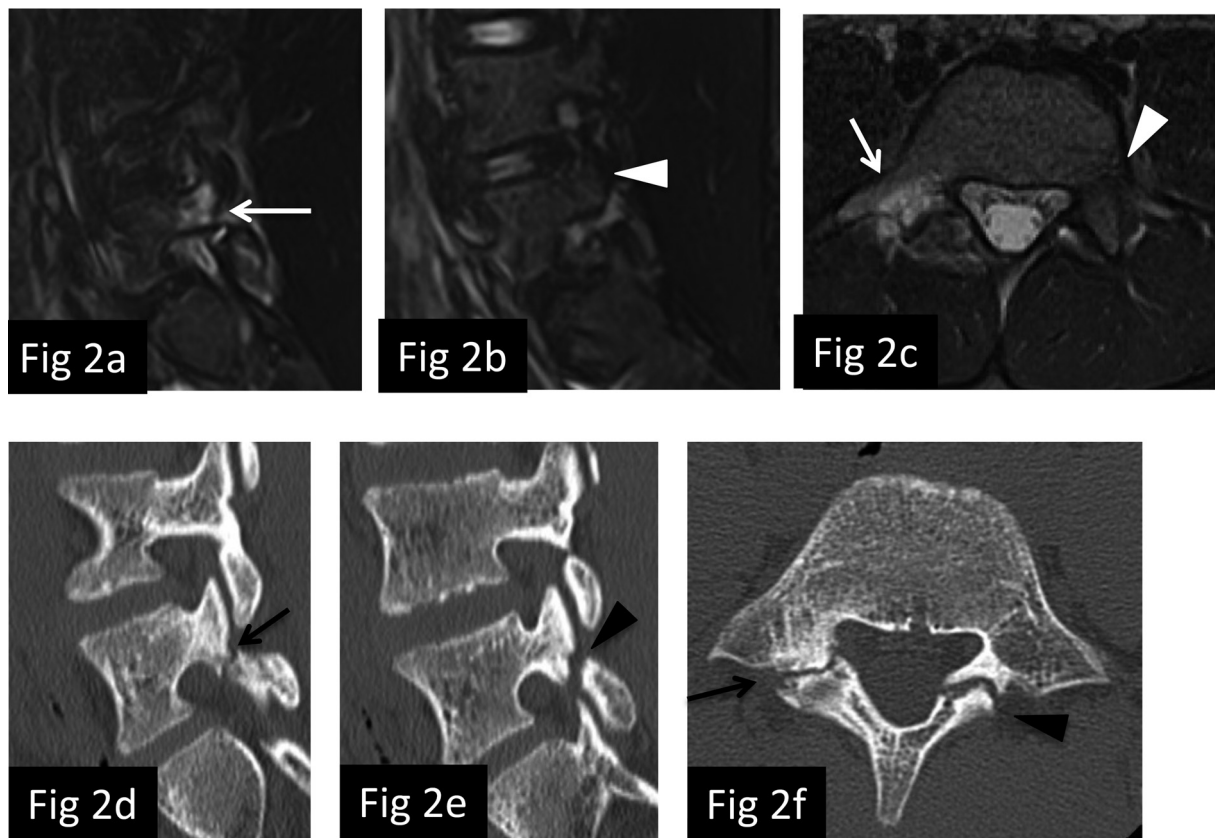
Case 1 at his first visit to the hospital. a–c) MRI STIR showed bone marrow edema on the right side only, around the pedicle (white arrow), and was normal on the left side (white arrowhead). d–f) CT showed an incomplete bony cleft on the right side (black arrow) and a complete cleft on the left side (black arrowhead). MRI STIR, magnetic resonance imaging short-tau inversion recovery; CT, computed tomography. (a and d: sagittal slices on the right, b and e: sagittal slices on the left, and c and f: axial slices on L5.)
